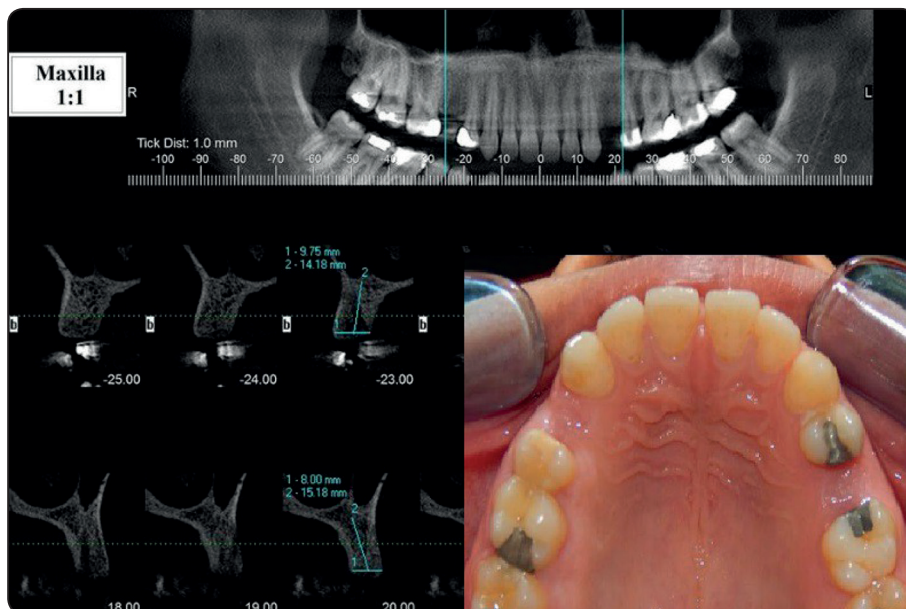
Preoperative clinical photograph and Cone Beam Computed Tomography of the same case
